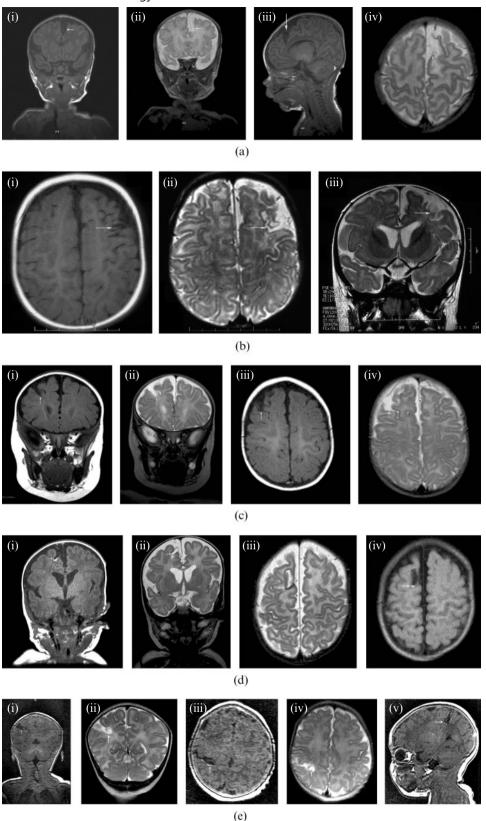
MRI appearances of cortical tears. (a) Case 1. (i) Coronal T_1 and (ii) coronal T_2 weighted images showing a cortical tear in the left superior frontal gyrus. (iii) Sagittal T_1 weighted image. (iv) Axial T_2 weighted image. (b) Case 2. (i) Axial T_1 and (ii) axial T_2 weighted images demonstrating a cortical tear in the left superior frontal gyrus. (iii) Coronal T_2 weighted image. (c) Case 3. (i) Coronal T_1 and (ii) coronal T_2 weighted images demonstrating a cortical tear in the right superior frontal gyrus. (iii) Axial T_1 and (iv) axial T_2 weighted images. (d) Case 4. (i) Coronal T_1 and (ii) coronal T_2 weighted images demonstrating a cortical tear in the right superior frontal gyrus. (iii) Axial T_2 weighted image and (iv) axial FLAIR image. Blood products can be seen at the edge of the tear as T_1 /FLAIR (fluid-attenuated inversion recovery) hyperintensity and T_2 hypointensity. (e) Case 5. (i) Coronal T_1 and (ii) coronal T_2 weighted images demonstrating a cortical tear in the right anterior parietal lobe. (iii) Axial T_1 and (iv) axial T_2 weighted images. (v) Sagittal T_1 weighted image. Diffusion weighted imaging in this patient showed no evidence of restricted diffusion.
